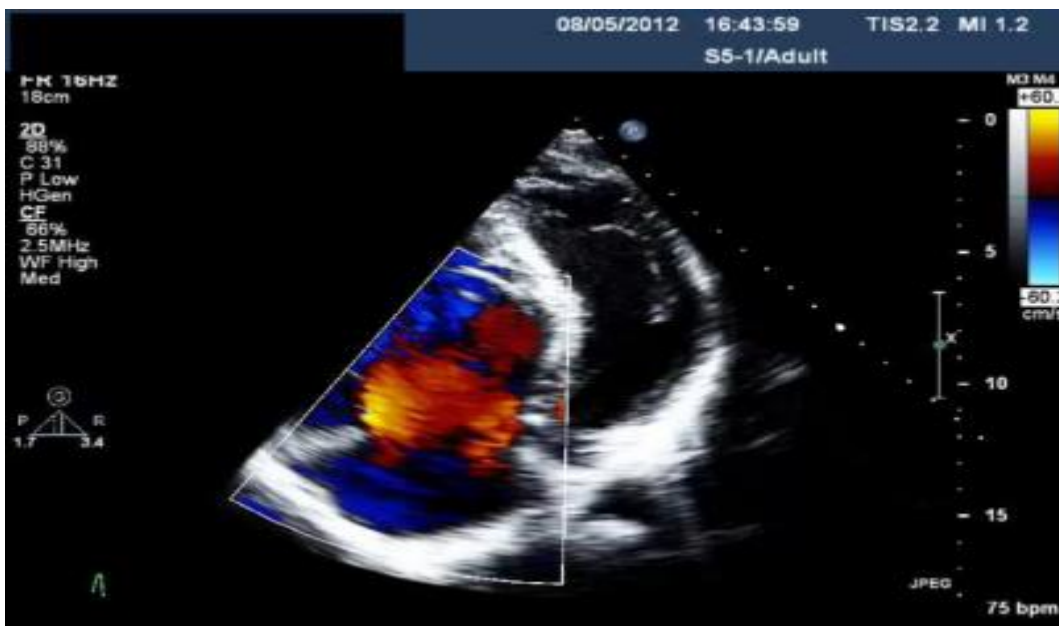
Colour doppler showing showing an associated ventricular defect causing high velocity in a highly situated right atrium.
